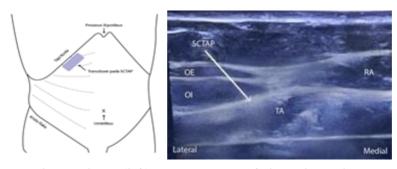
Position of ultrasound transducer (left); Sonoanatomy of the subcostal approach to the transversus abdominal plane (TAP) block (right).
